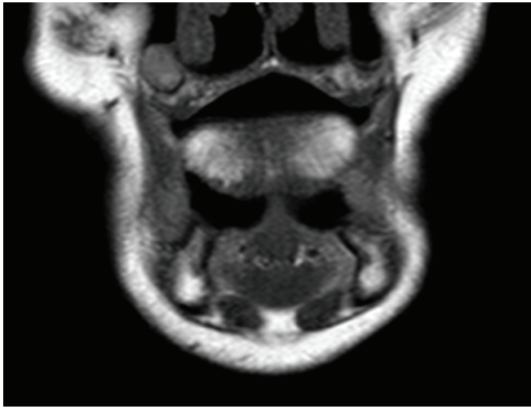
T1W2 MRI shows diffuse high intensity area on the tongue.
